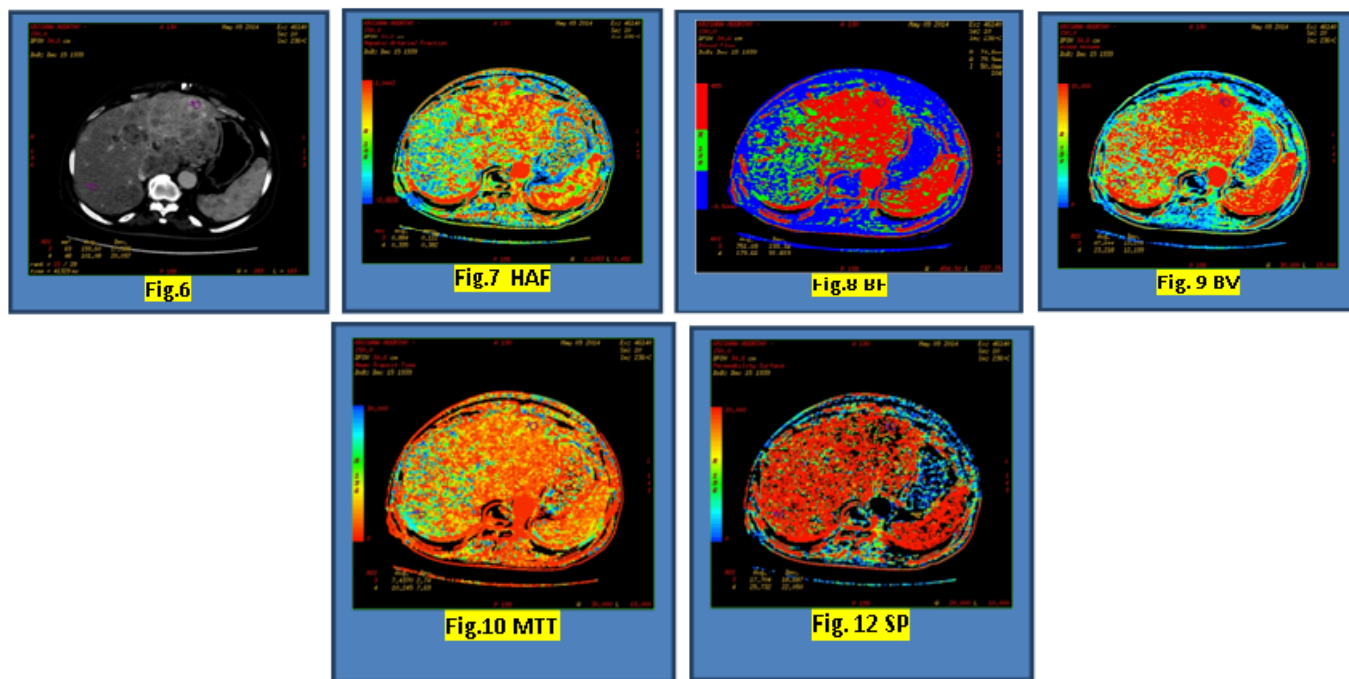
CT Perfusion in Hepatocellular Carcinoma
